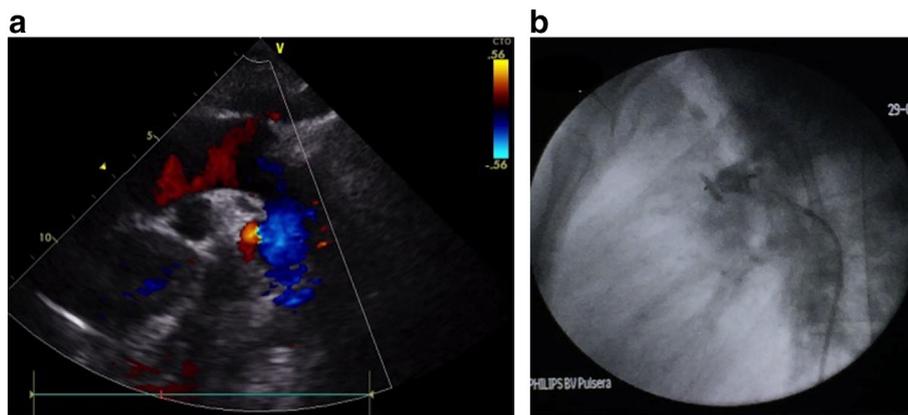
A: Trans-thoracic echocardiography showing patent ductus arteriosus. B: Post-placement hand-angiography from aortic end of ductus showing complete occlusion.
